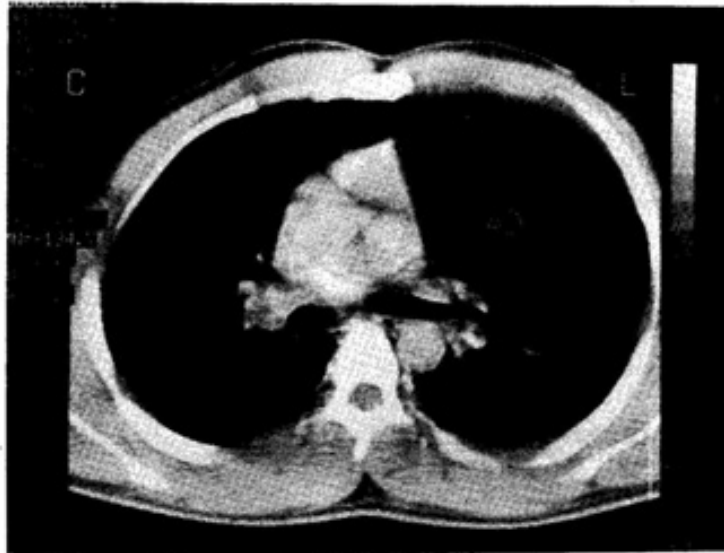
Preoperative CT scan of the chest demonstrating the pericardial mass.
